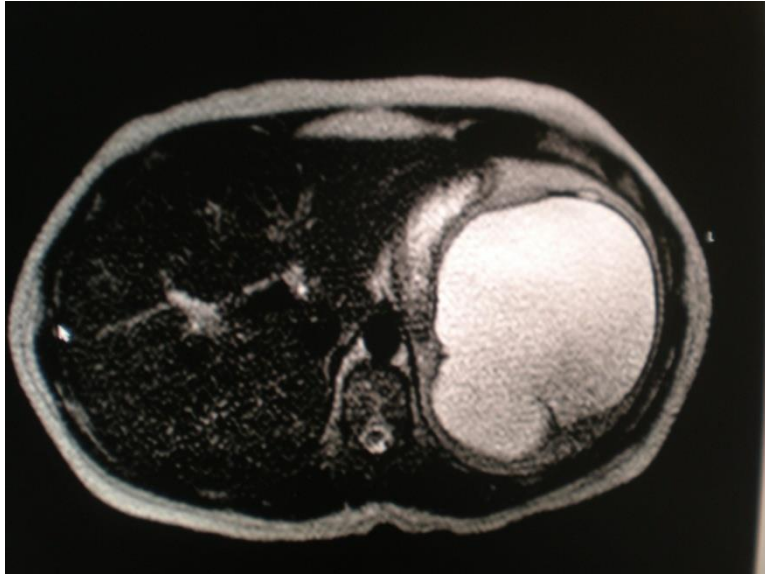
MRI of abdomen T2WI showed giant hydrated cyst in spleen with three layers differentiation.
